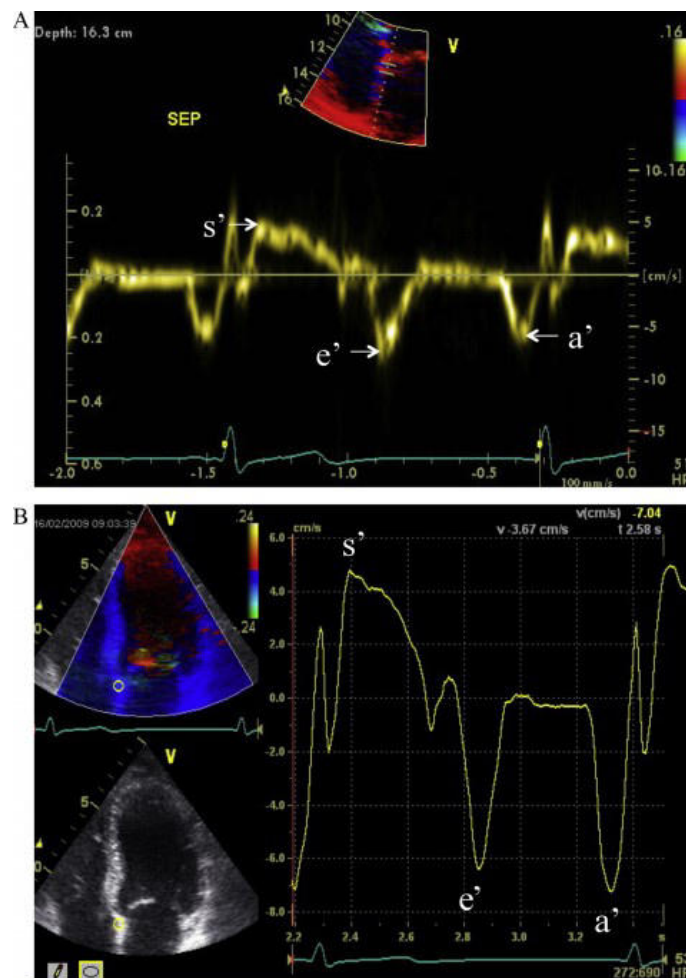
Standard Tissue doppler imaging (TDI) acquisition. A: pulsed wave imaging recording from the apical four chamber view sampling from the mitral valve. B: color doppler imaging recording from the apical four chamber view sampling from the mitral valve. In both
